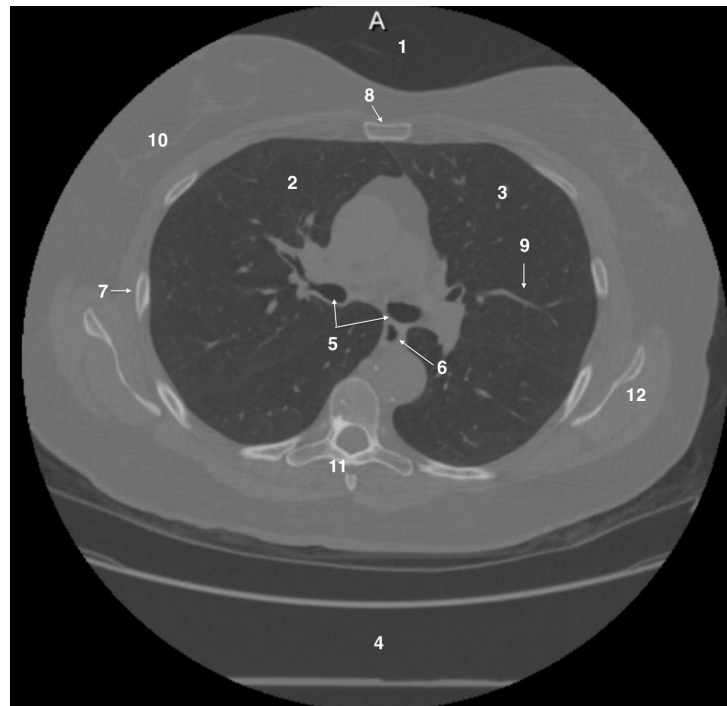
Slice of a chest CT exam. The principal organs and structures are labeled: 1) Air outside the patient's body, 2) Right lung, 3) Left lung, 4) Table of the scanner, 5) Trachea and large airways, 6) Esophagus, 7) Rib, 8) Sternum, 9) Blood vessels, 10) Fat tissue (patient's body), 11) Spine, 12) Scapula.
